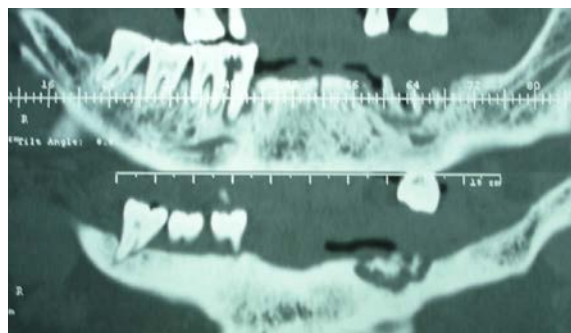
Cone beam computed tomography after one year.
